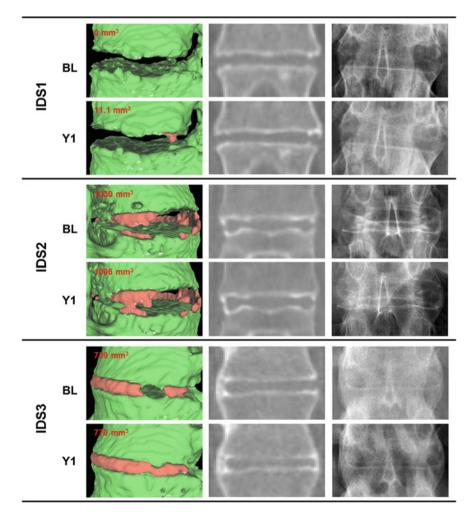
Examples of syndesmophyte progression from baseline (BL) to year 1 (Y1). From *left* to *right* 3D surface mesh (syndesmophytes in red and vertebral bodies in green), CT slice, radiograph
